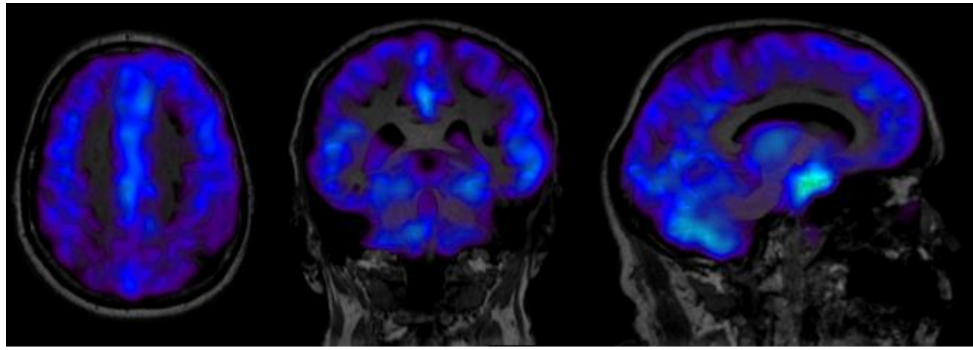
Rotated Gaussian Filtered PET Water Dynamic Co-Registered with an MRI Scan.
